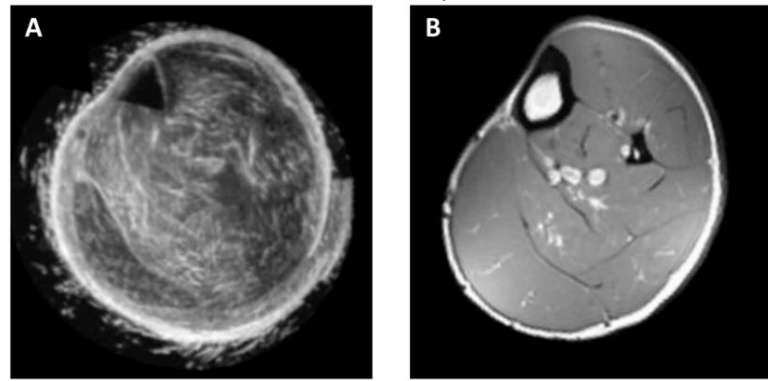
Transverse slice of lower limb using, A: ultrasound with limb motion compensation and B: MRI (NOTE these two slices are not directly comparable) [201] Copyright © 2015, IEEE
